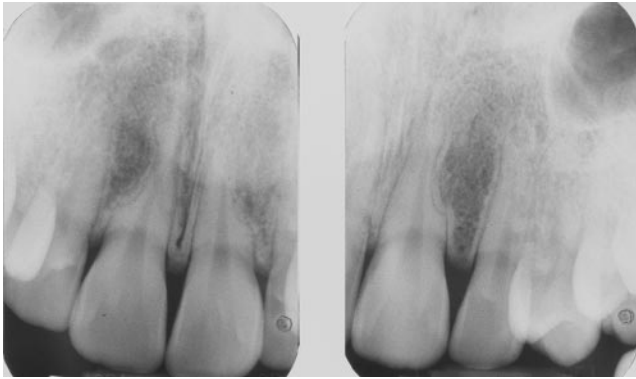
Six years posttreatment periapical radiographs of maxillary central incisors.
